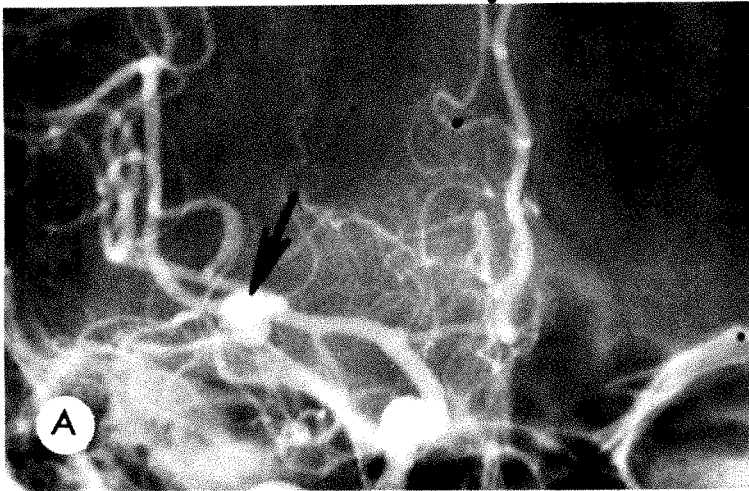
Subarachnoid hemorrhage; development of neurologic deficit without recurrent hemorrhage. *A*, Right carotid angiogram on day 1 showing middle cerebral artery aneurysm (arrow), spasm, and midline shift. *B*, CT scan 6 days later showing infarct with swelling in distribution of right middle cerebral artery (arrow). Note resorbing (previously present) hematoma (arrowhead).
